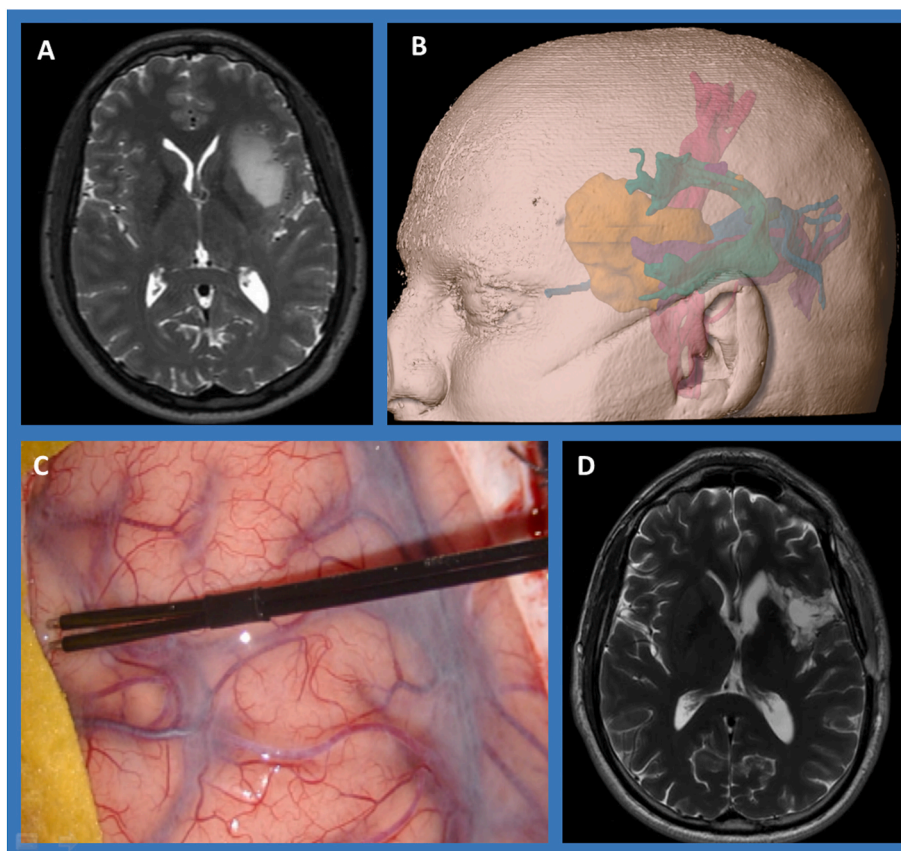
Case example of low-grade insular glioma. A: T2 sequence MRI shows hyperintense left fronto-insular lesion. B: 3D reconstruction with skin projection of the lesion, in orange, and the surrounding tracts: corticospinal in fuchsia, optic in light blue, arcuate in green and in violet the lower fronto-occipital. C: cortical mapping with bipolar probe. D: Postoperative T2-weighted MR with minimal remnant adjacent to the frontal horn of the lateral ventricle.
